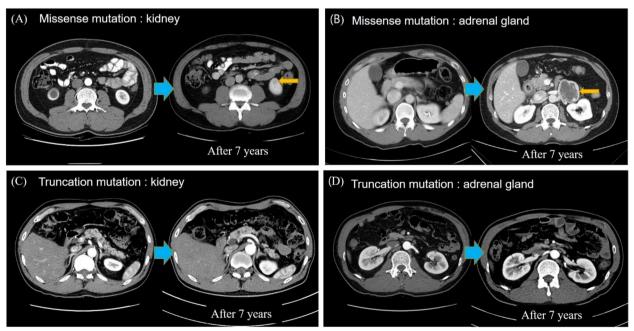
Baseline and follow up (7-year) axial CT images from two patients of the same age and sex: one with a missense mutation and one with a truncation mutation. A A male patient in his early 50 s with a missense mutation and no RCC on baseline CT developed a small RCC (1.0 cm) in upper pole of the right kidney on follow-up CT scan. B He also developed a large pheochromocytoma (6.2 cm) in the left adrenal gland. (C & D) Another male patient of the same age with a truncation mutation had no RCC nor adrenal pheochromocytoma on a baseline CT scan. The patient had developed no new lesion at the time of follow-up CT
